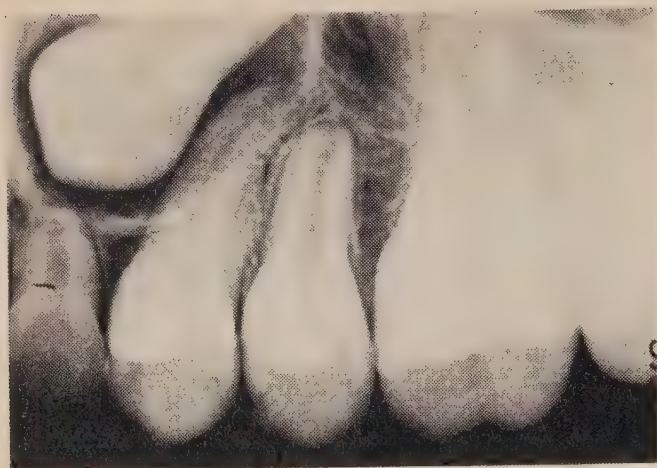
Radiographie périapicale préopératoire montrant la dent incluse et la lésion.
